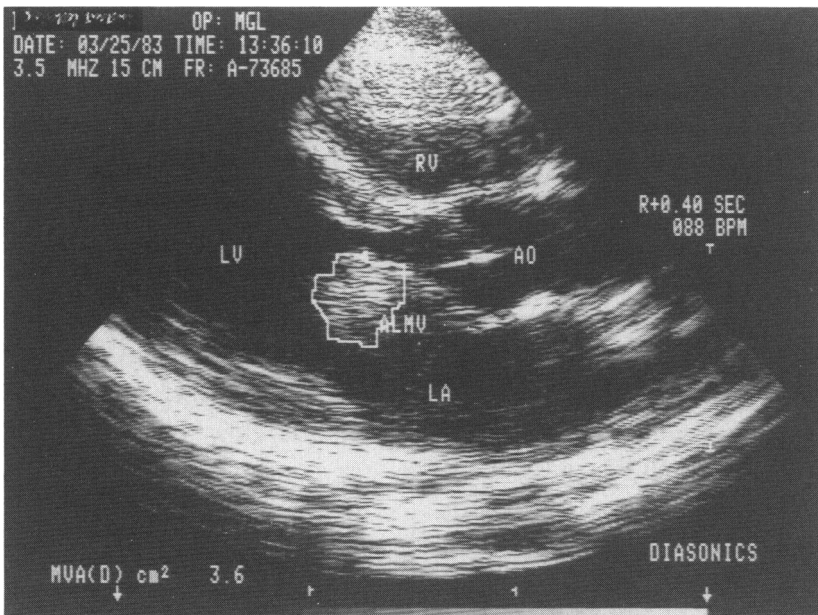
Mitral valve vegetation. In this parasternal long axis view, a large vegetation is seen on the anterior leaflet of the mitral valve (ALMV). A vegetation is seen as a fluffy, white density attached to the valve.
